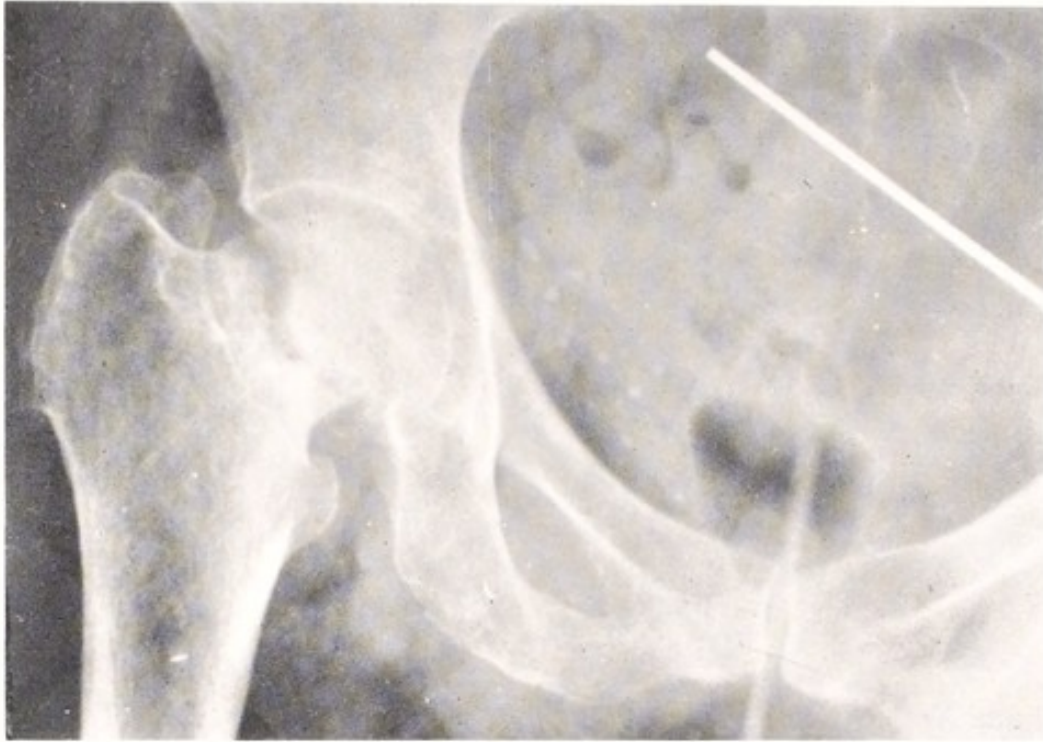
Wisdom of either threading nails or placing nuts upon them is shown by this x-ray which shows a Kirschner wire which has wandered into pelvis. (Courtesy of Dr. Austin Moore.)
